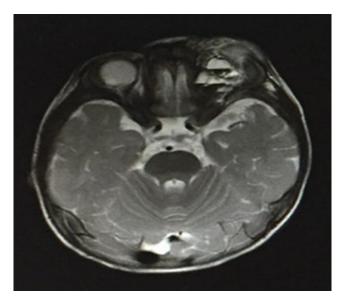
Showing hyper dense area of haemorrhage in the left orbit on T2 MRI
